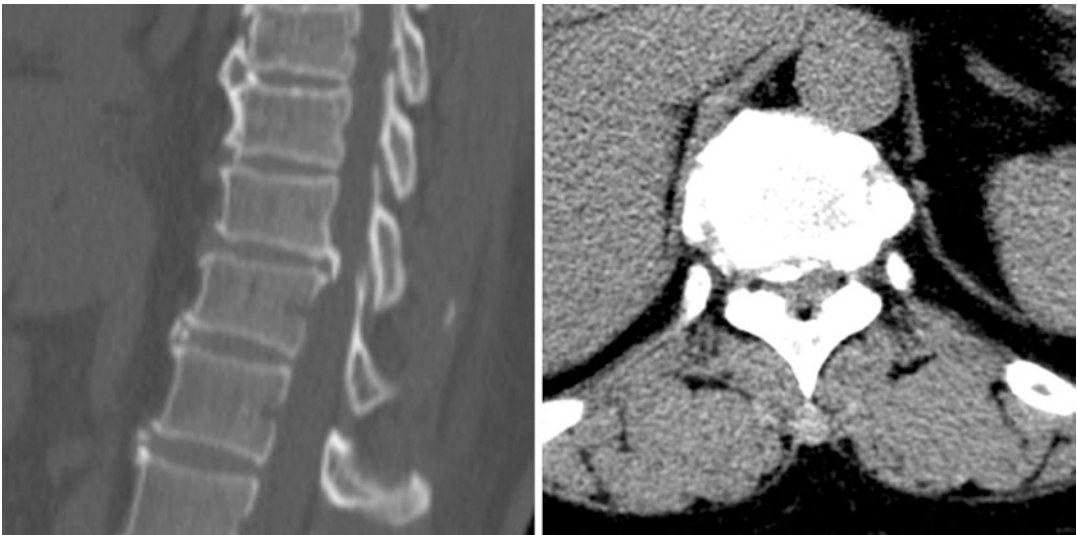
Preoperative CT images
